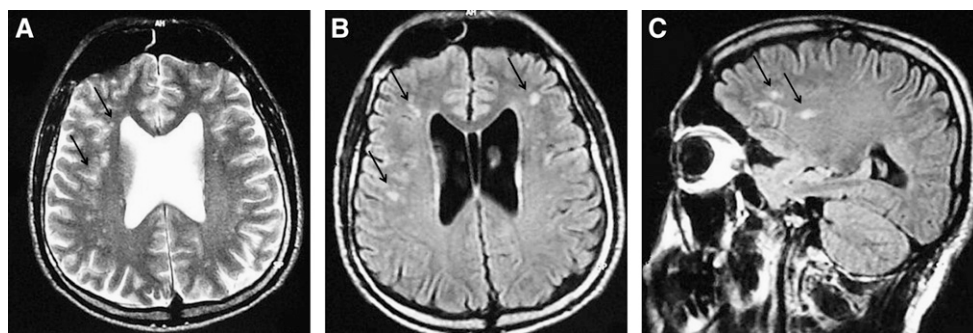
Multiple hyperintense gliotic lesions in the periventricular area in a 43-yr-old military diver diving for 19 yr. A) T2-weighted axial image, B) axial, and C) sagittal FLAIR sequences.
